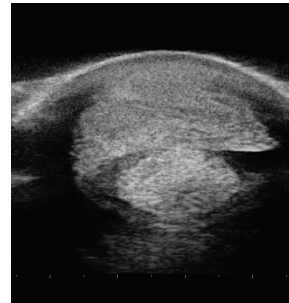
Ultrasound image of the front left limb after 8 sessions of INDIBA®
